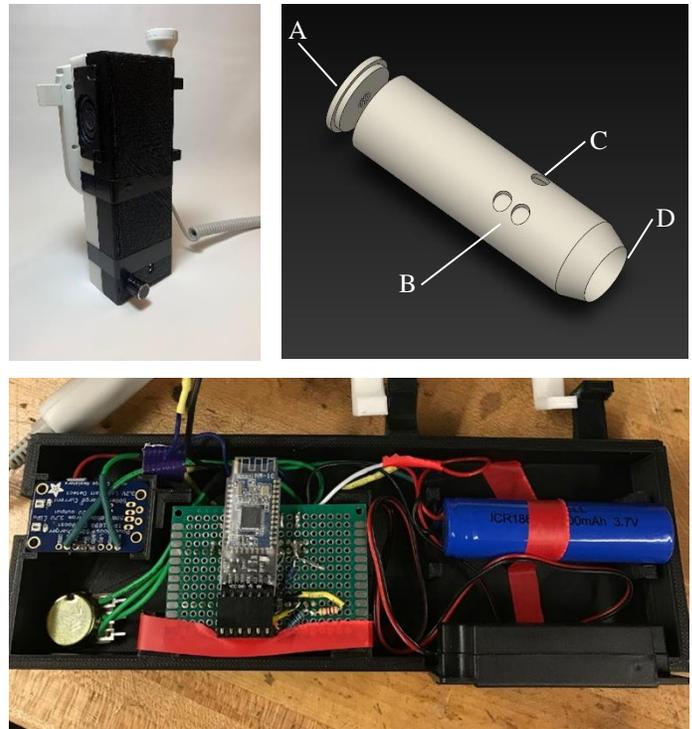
Vascular Doppler Prototype. Top Left: The current prototype of the improved vascular Doppler. Top Right: A Computer-Aided-Design Model of the next design of the vascular Doppler with parts labeled: A) speaker, B) volume adjustment controls, C) power control, and D) transducer. Bottom: Electronic components consolidated and soldered in a 3-D printed housing.
